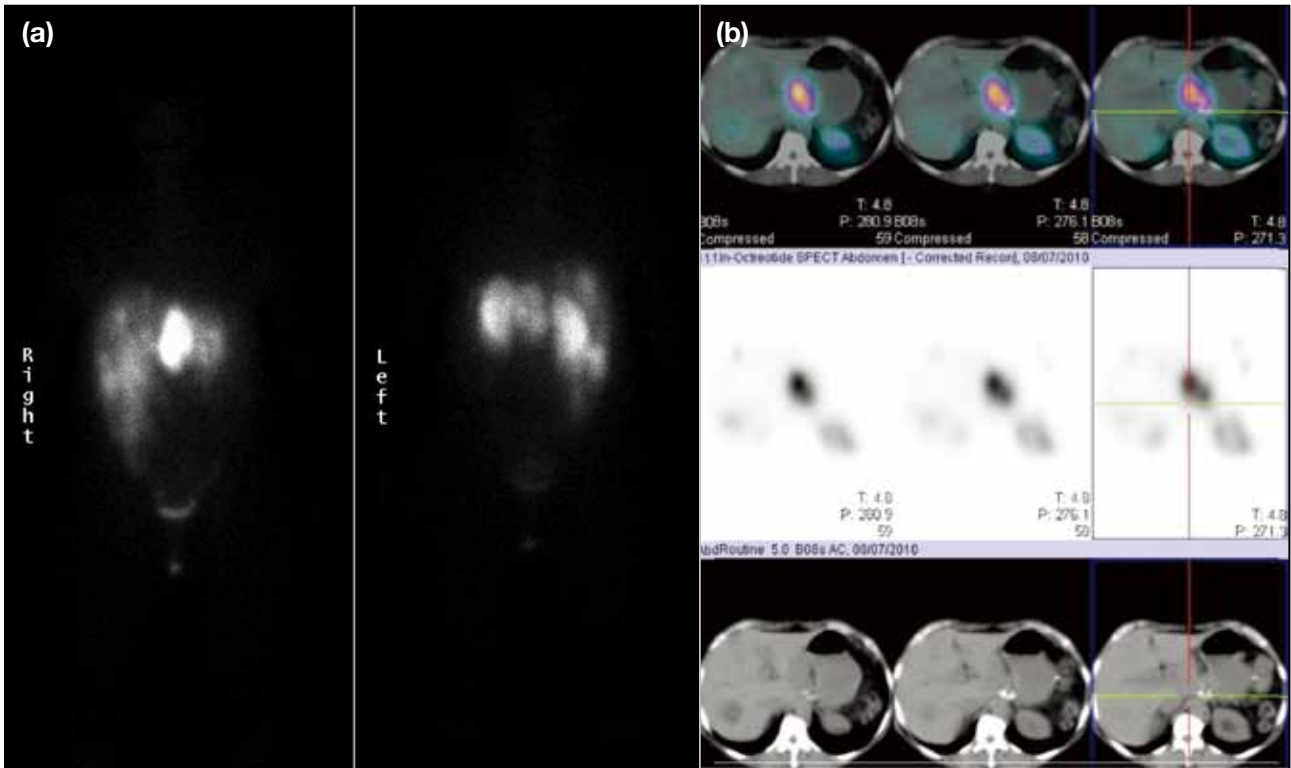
(a) A patient with known metastatic pancreatic neuroendocrine tumour showing the octreotide avid lesions in the liver and in the mid abdomen on the whole-body ^{111}In pentetreotide images. (b) The single-photon emission computed tomography–computed tomography (SPECT-CT) ^{111}In -pentetreotide images show several liver metastases and pancreatic mass (note: fused images in top row, ^{111}In -pentetreotide images in middle row and CT bottom row).
